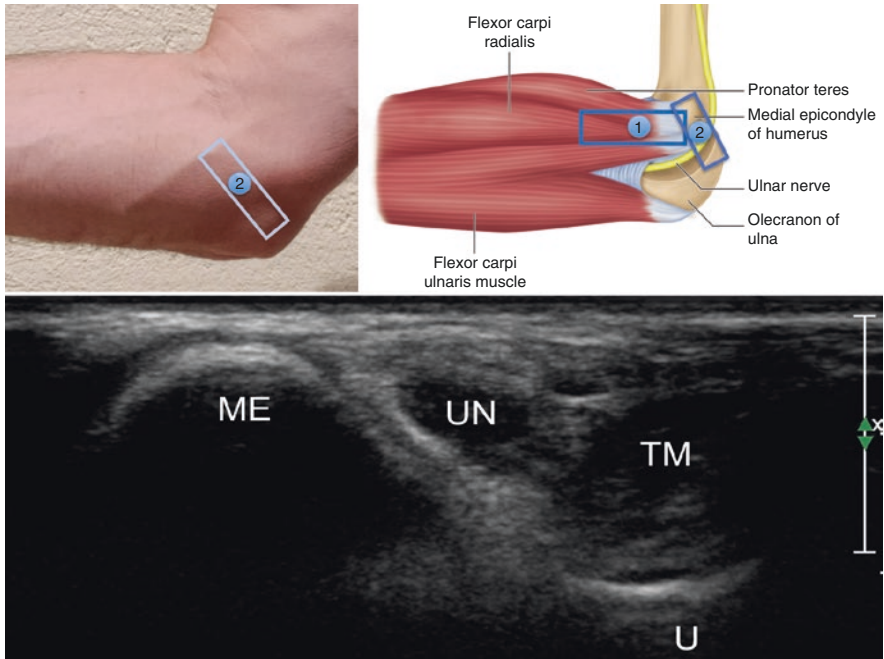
Sonoanatomy of the medial elbow with the ultrasound probe in scan position 2
